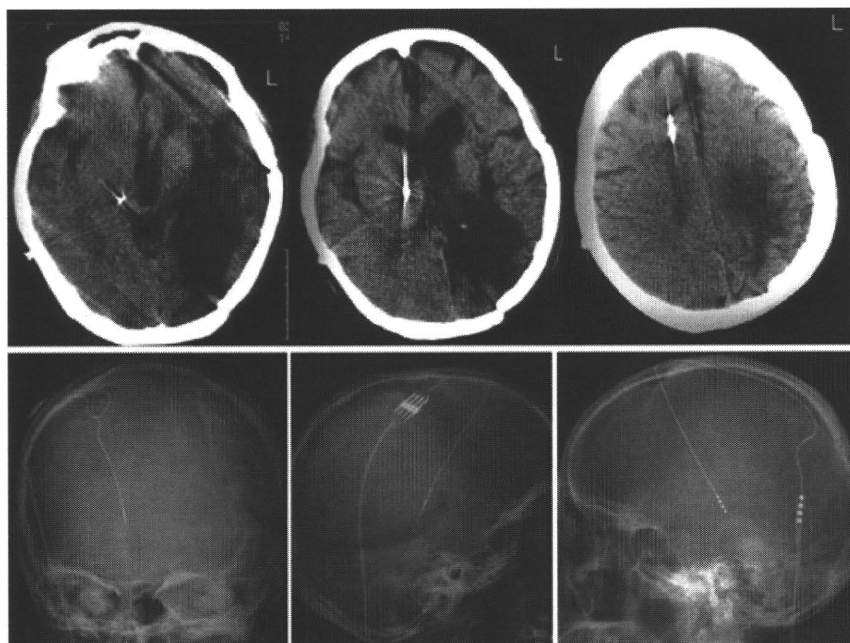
Deep brain stimulation for treatment of a VS patient. The stimulating electrode was implanted for CM-pf stimulation. Computerized tomography (upper) and radiography (lower left and middle) show the trajectory and location of the old type of DBS electrode. Lower right indicates the present DBS electrode.
